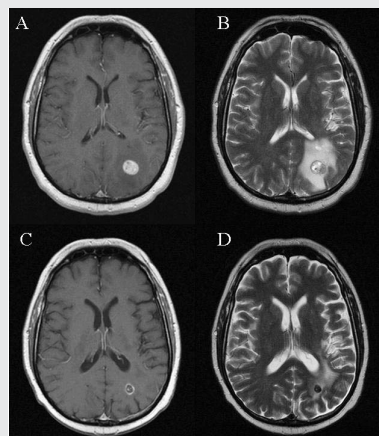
46-year-old male with history of renal cell carcinoma diagnosed five years prior to presenting to the emergency department with a three-day history of hand clumsiness and difficulty with ambulation. MRI of the brain demonstrated three brain metastases, T1 weighted image with gadolinium contrast (A) and T2 weighted image (B) demonstrating the 2-cm left occipital homogeneously enhancing lesion with associated edema. MRI of brain one year and eight months after Gamma Knife stereotactic radiosurgery (C and D) showed marked decrease in tumor size and contrast enhancement with associated decrease in edema.
